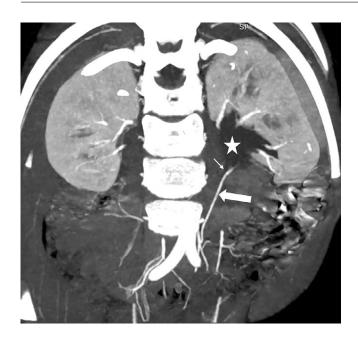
Contrast enhanced abdominal CT scan in arterial phase; coronal oblique reconstruction, showing the inferior mesenteric artery aberrant branch (thick white arrow) crossing the left uretero pelvic junction (thin white arrow) causing left renal pelvic dilatation (white star).
